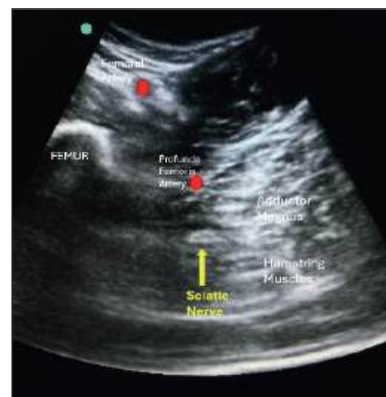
Ultrasonographic view of sciatic nerve.
